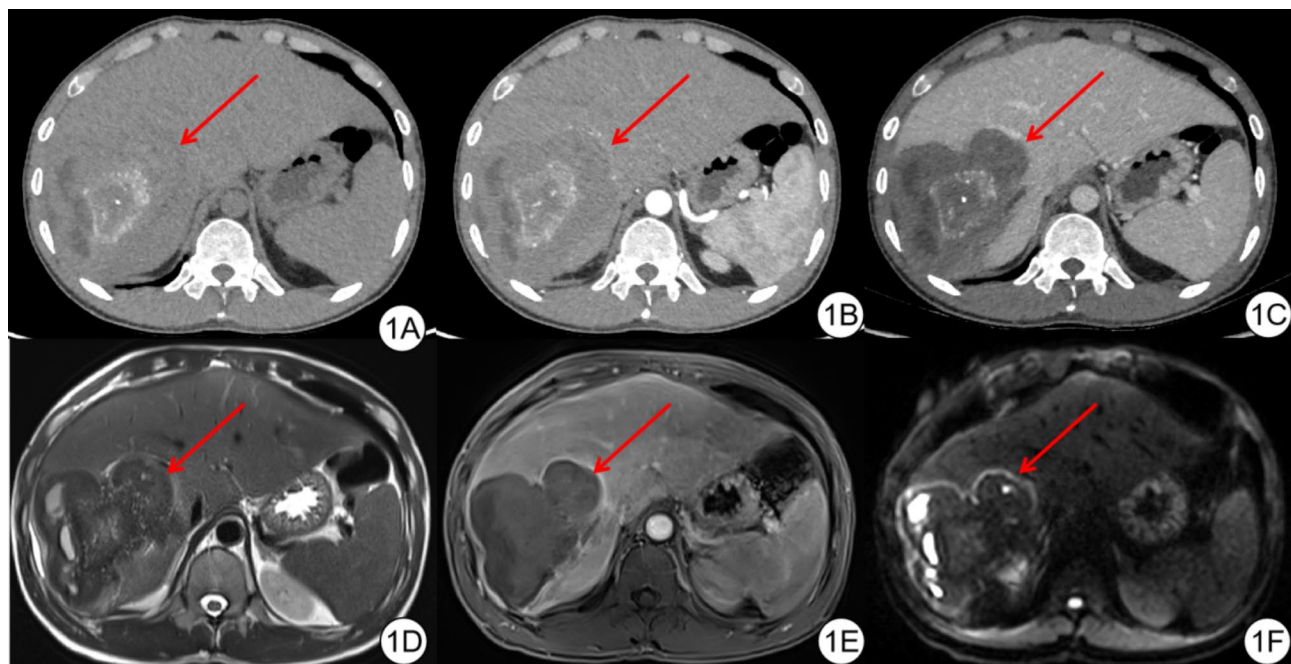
Imaging manifestations of HAE, (A): the non-contrast CT scan shows a lesion in the liver's S6 segment with mixed density and unclear borders. (B): During the arterial phase of contrast-enhanced CT, the lesion in liver segment S6 appears non-enhancing, with mild enhancement of the surrounding liver parenchyma, resulting in better delineation of the lesion borders. (C) During the venous phase of contrast-enhanced CT, the lesion in liver segment S6 shows no significant enhancement, while there is marked enhancement of the surrounding liver parenchyma, leading to a clear delineation of the lesion borders. (D) T2WI shows a liver lesion in segment 6 with a mixed high and low signal intensity, with clear borders. (E): Contrast-enhanced T1WI shows no noticeable enhancement in the liver lesion of segment 6, with an enhanced rim at the edge. (F): DWI shows a liver lesion in segment 6 with mixed high and low signal intensity and a rim of high signal intensity at the edge.
